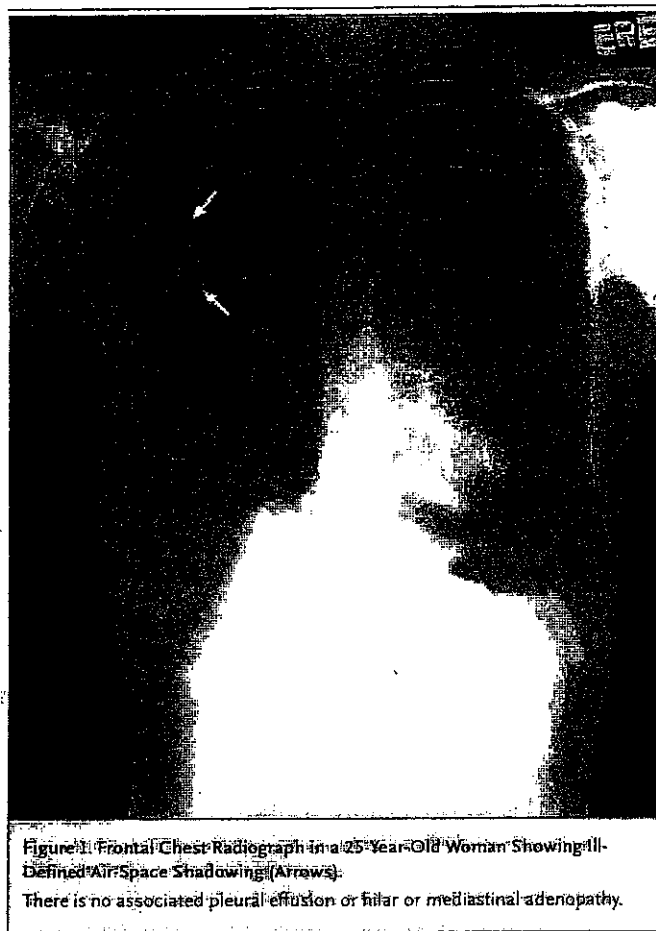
Frontal Chest Radiograph in a 25-Year-Old Woman Showing Ill-Defined Air-Space Shadowing (Arrows). There is no associated pleural effusion or hilar or mediastinal adenopathy.
